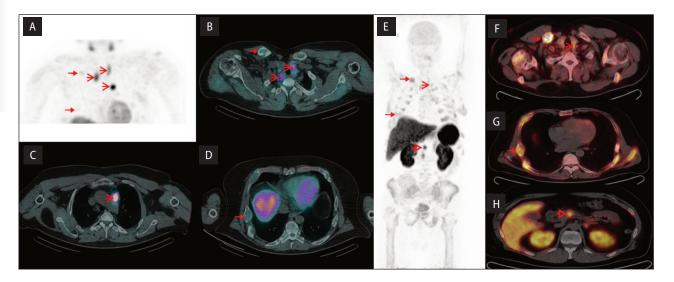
99m technetium-sestamibi single-photon emission computed tomography/computed tomography ([^{99m}Tc]Tc-MIBI SPECT/CT) — scintigraphy. A. Maximum intensive projection (MIP); B., C., D. Fusion SPECT/CT. Gallium 68-tetraazacyclododecane-tetraacetic acid-octreotate positron emission tomography computed tomography ([68Ga]Ga-DOTA-TATE PET/CT); E. MIP; F., G., H. Fusion PET/CT
